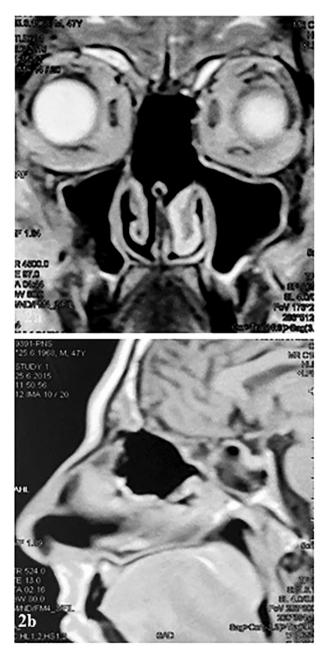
Postoperative coronal T2 MRI (a) and sagittal T1 MRI post-contrast (b) of the first case showing complete resection of the tumor with mild scarring at the frontal recess area.
